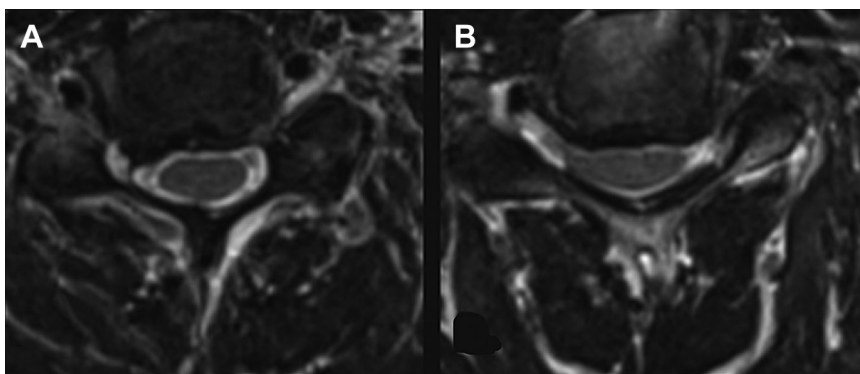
Axial T2-weighted magnetic resonance imaging (MRI) scans of the cervical spine demonstrate (A) laterally herniated disc to the right with compression of the exiting nerve root and (B) a centrally located disc/osteophyte causing both spinal cord and nerve-root compression.
